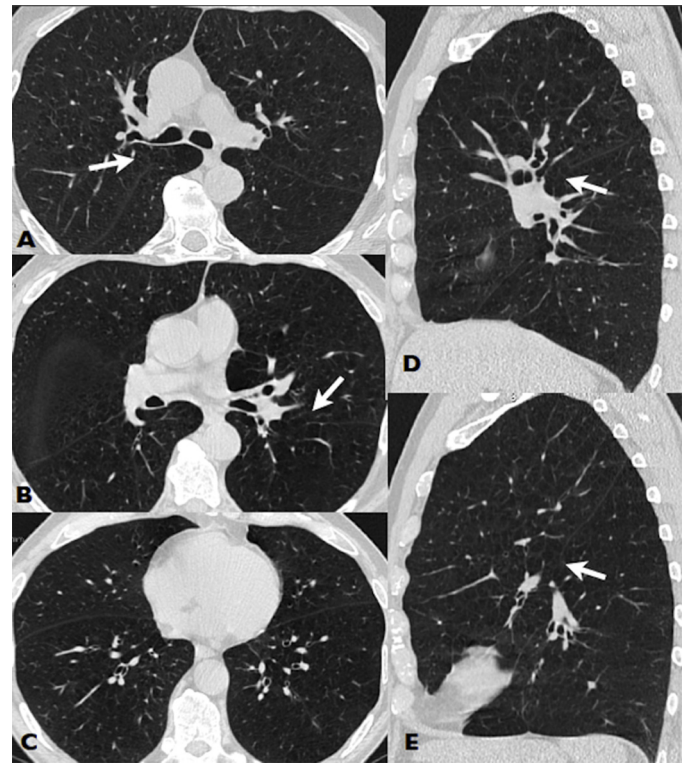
Example of thin-section CT images (lung window) of a subject with COPD GOLD category 2, emphysema and incomplete oblique fissures, with small fissure gaps. Small medial fissural defects of approximately 2–3 cm were identified by both readers in the upper half of the right oblique (RO) fissure (arrow in A) and in the middle third of the left oblique (LO) fissure (arrow in B). Sagittal reformatted images (right side in D and left side in E) help to assure the presence of fissural defects (arrows). In this case, one reader assigned the subject as having both oblique fissures 90% complete (10% fissural defect), while the second reader assigned an integrity of 90%/95% for the RO/LO fissure. As they agreed regarding the fissures status (complete vs. incomplete) and defects location, no consensual reading with a third reader was necessary. Finally, to include in the population description of prevalence and severity of incomplete fissures, integrity for this subject was assigned as 90%/93% (average between both readers) for the RO/LO, respectively.
